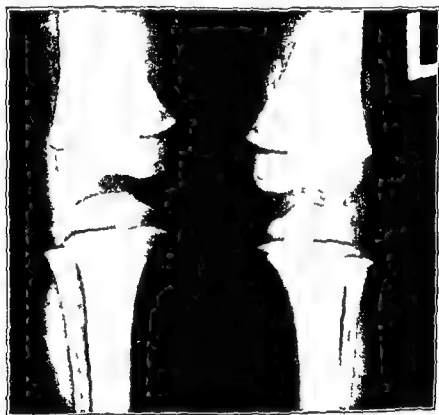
X-ray of the skull of a child suffering from lead poisoning. Note the lines of increased density at the ends of the bones.
